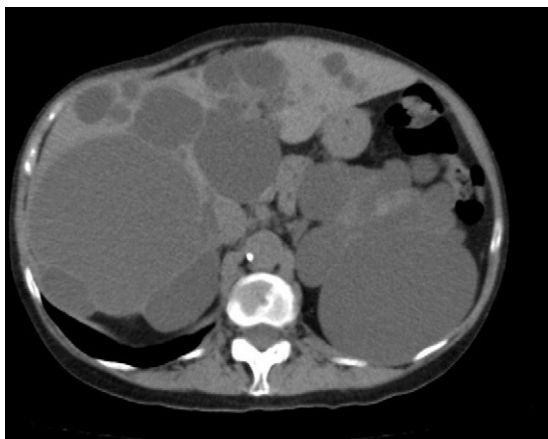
CT: polycystic liver disease.
